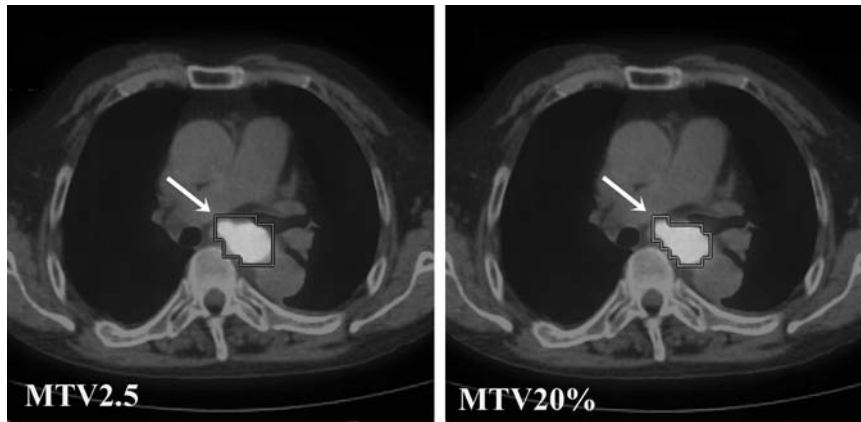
Metabolic volumes of the primary tumors of a T3 squamous cell carcinoma patient (arrow). The Positron emission tomography area was delineated by an isocontour with a Standardized uptake value maximum of 2.5 (MTV2.5) (a) and 20% of SUV_{max} (MTV20%) (b).
